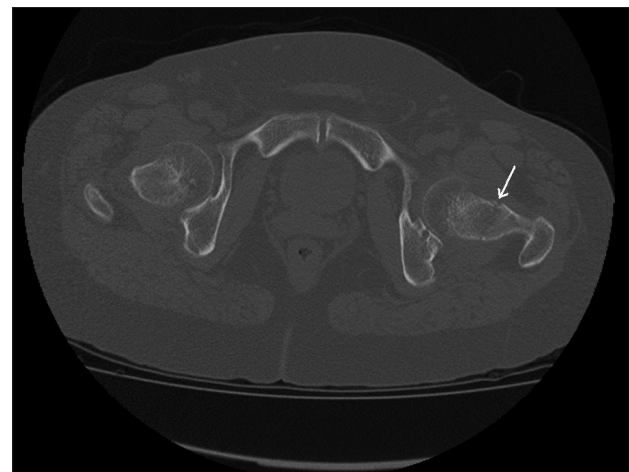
Left femoral neck fracture (arrowed) visible on CT images
